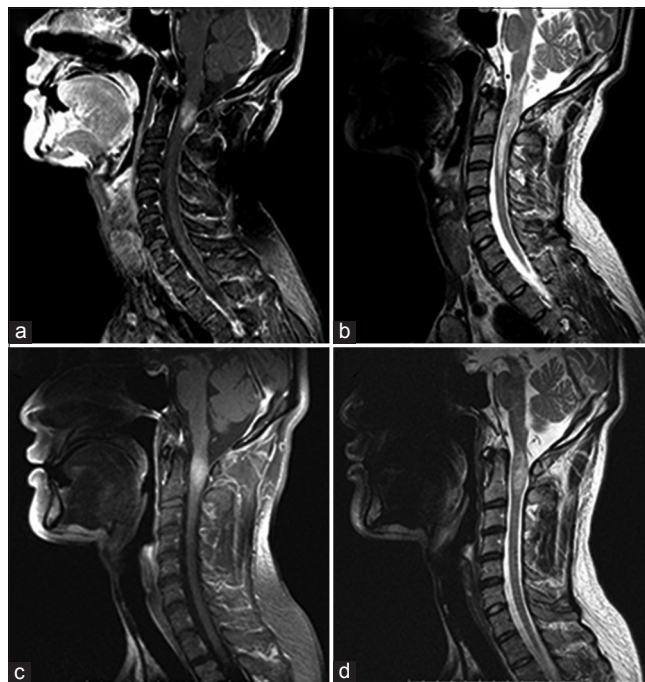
(a) Sagittal T1-weighted postgadolinium magnetic resonance (MR) images through the cervical spine showing intense contrast enhancement of an intramedullary lesion from the C1 to C2 level. (b) Sagittal T2-weighted MR images demonstrating the heterogeneous intramedullary lesion extending from the medulla oblongata to the C4 level, which was thought to represent spinal cord edema surrounding the enhanced mass. (c and d) Scans after steroid pulse therapy. (c) Sagittal T1-weighted postgadolinium MR images showing no change in the enhanced lesion. (d) Sagittal T2-weighted MR images showing a decrease in cord edema.
